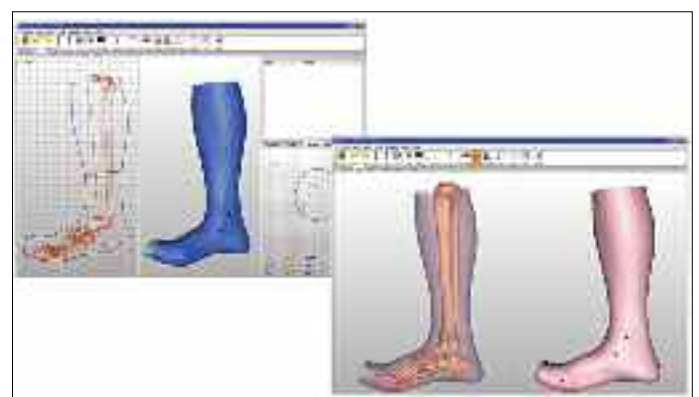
Canfit-X Design: New Developments in FootWare Align foot imprints, photos, -x-rays and MRI Images.
